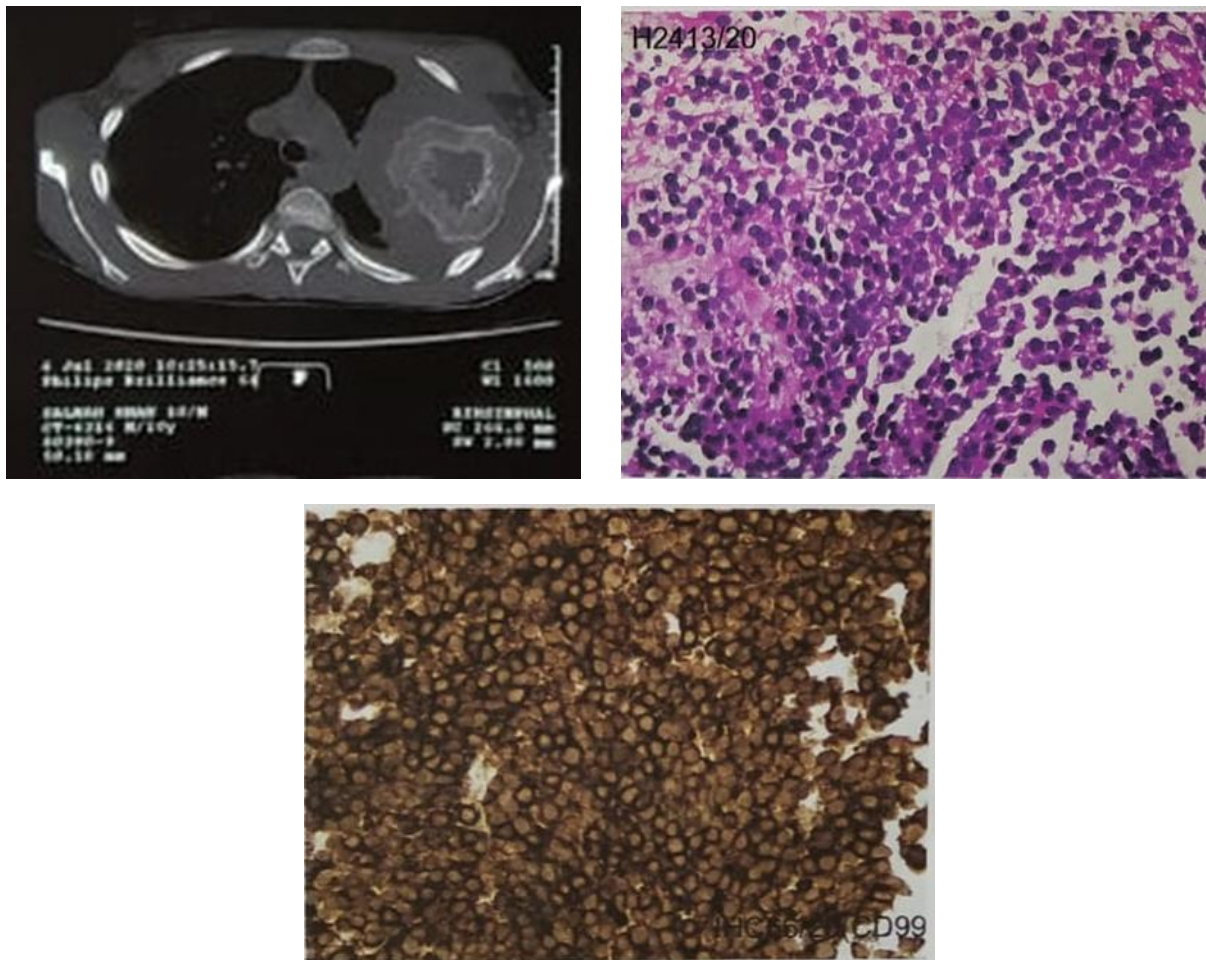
Askin Tumor. (a) Swelling over left chest wall. (b) Massive pleural effusion. (c) HRCT thorax showing expansile lytic lesion with lobulated soft tissue component. (d) A small round cells malignant tumor with scanty cytoplasm and hyperchromatic nuclei arranged in sheets, clusters, and peritheliomatous patterns. (e) CD99/MIC-2 positive.
